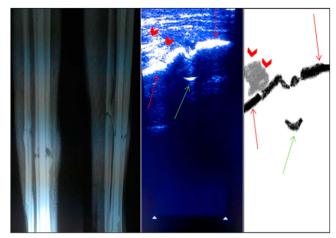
A 37-year-old patient with nonunion radiograph at 24 weeks postoperatively showing nonunion of tibia fracture; ultrasonography (original and animation) at 16 weeks postoperatively showing bone cortex (red arrows), nail (green arrow), and minimal periosteal soft callus predicting nonunion of fracture.
